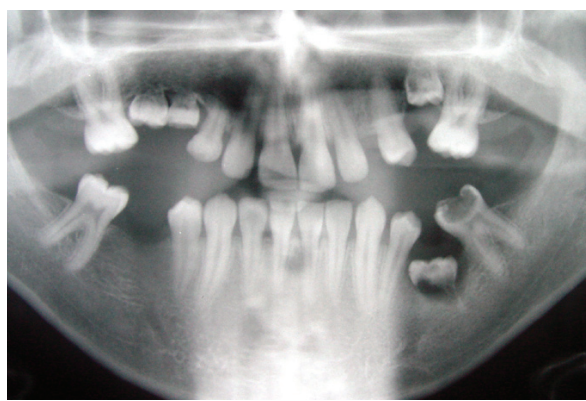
The panoramic radiograph of Twin DHH.
